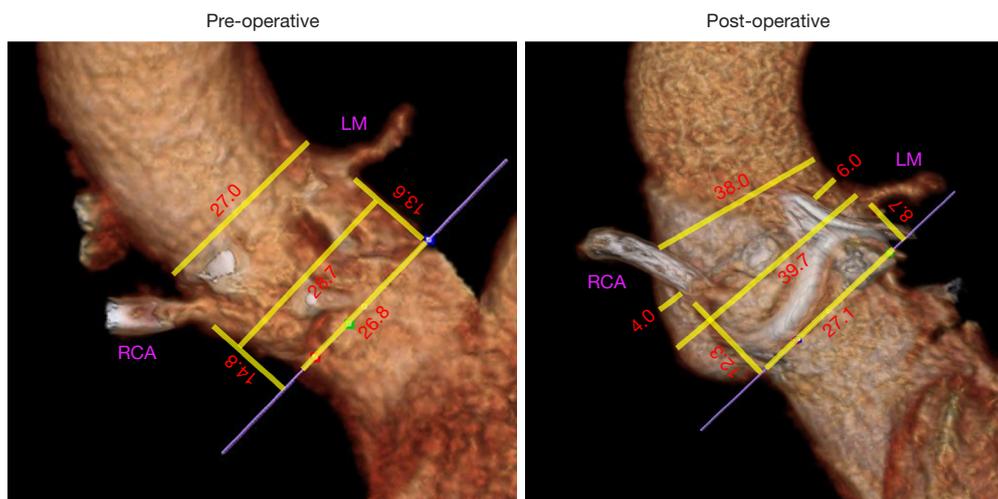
Representative example with 3D renderings of the aortic root from pre-operative (left) and post-operative (right) CT scans, demonstrating typical changes in the anatomy observed with Y-incision ARE, including significant enlargement of the sinus widths (+11 mm in this case) and STJ with upsizing by three valve sizes (implanted 29 mm Maga Ease). RCA, right coronary artery; LM, left main; 3D, three-dimensional; CT, computed tomography; ARE, aortic root enlargement; STJ, sinotubular junction.
